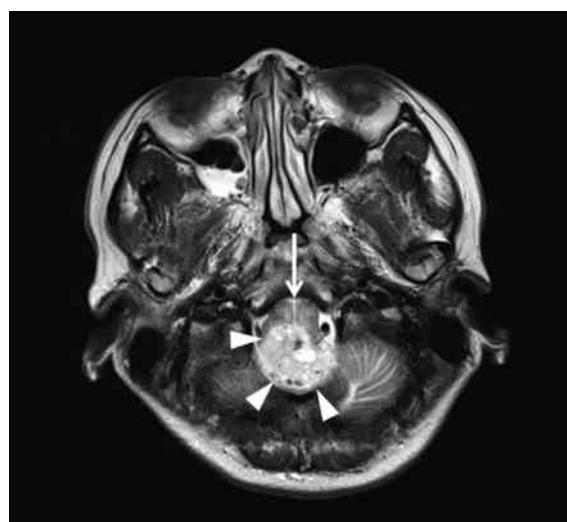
Preoperative T2-weighted MRI scans, showing a large tumor (white arrowheads) located on the dorsal medulla oblongata (white arrow).
